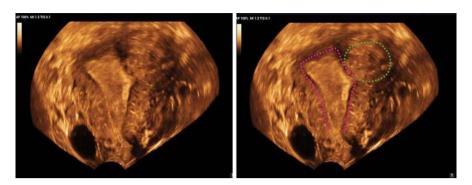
Coronal plane of the uterus on 3D ultrasound shows an adenomyoma in the left wall, in close proximity to the uterine fundus, where the junctional zone is interrupted. The adenomyoma is circled in green; the hypoechoic junctional zone surrounding the endometrium is circled in pink
